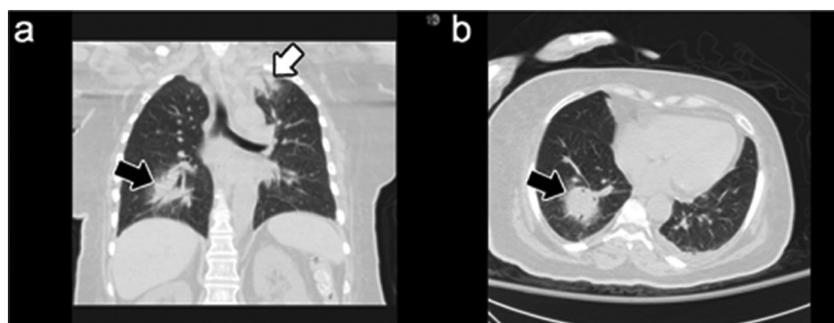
Chest computed tomography scan on day 37 showing a nodular infiltrate in the right lower lobe (black arrow) and a left upper lobe infiltrate (white arrow).
